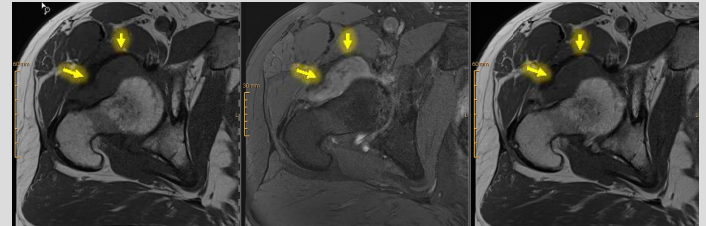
MRI right hip (T1 TSE TRA; T2 TRUFI; T1 TSE KM): T2 hyperintense and T1 isointense (to muscle) tumor anterior to femoral neck, slight peripheral contrast enhancement, no blooming in iron-sensitive sequences
